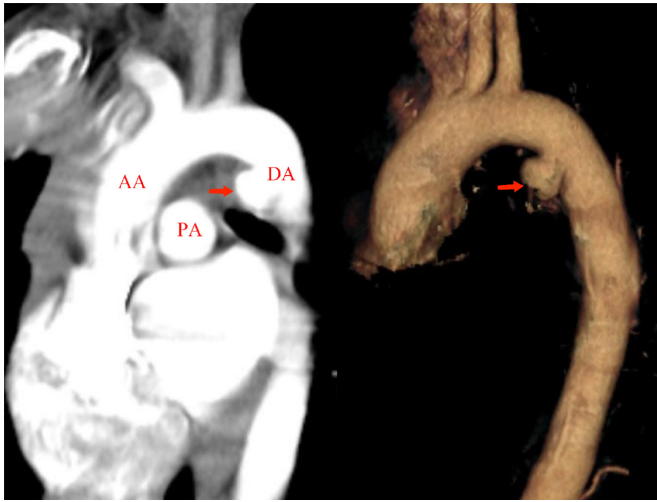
Computed tomography angiography suggested the formation of a pseudoaneurysm (red arrow) in the descending aorta next to the lesser curvature of the aortic arch. AA, ascending aorta; PA, pulmonary artery; DA, descending aorta
